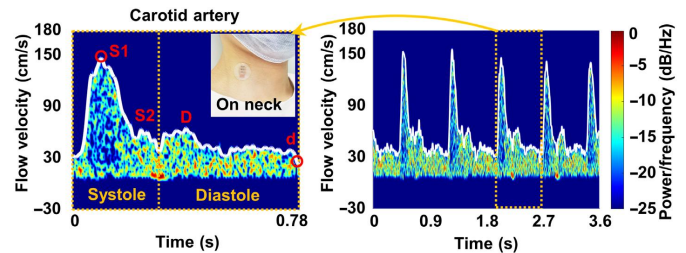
Ultrasonic spectrum for carotid artery [39].
